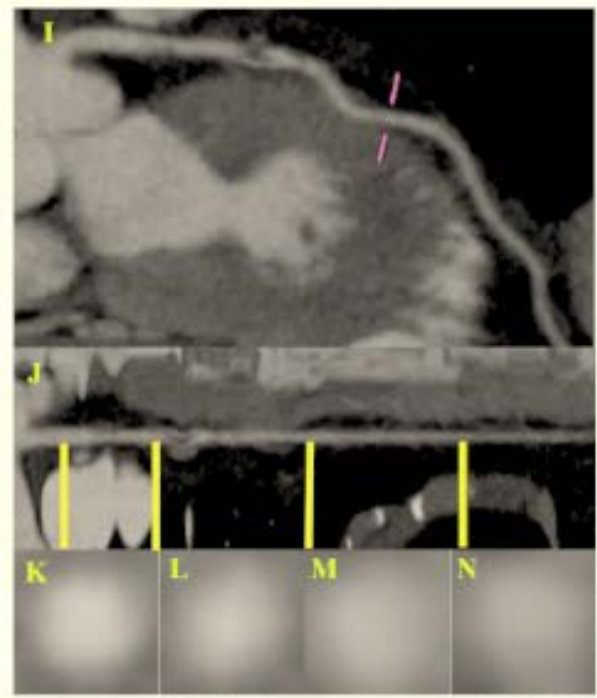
Example: Rest and stress CTA.
